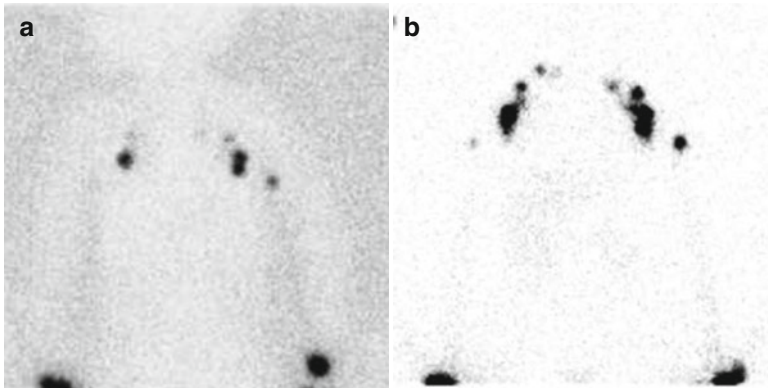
Normal lymphoscintigraphy of the upper extremities. A 1-year-old infant with fullness of the hands was referred for evaluation of possible lymphedema. (a) For the upper extremities, lymphoscintigraphy was performed after intradermal injection of filtered ^{99m}Tc -labeled sulfur colloid in the dorsum of each hand. (a) Within
